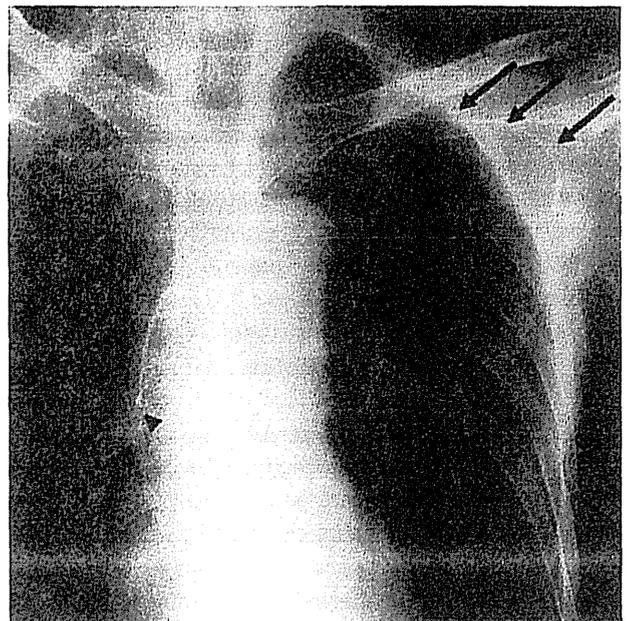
Chest X-ray of an ideally placed central venous port. The curve of the catheter is gentle, and the catheter tip (*arrowhead*) is adjusted to the level of the atriocaval junction. Note the short subcutaneous tunnel (*arrows*) between the venous access site and the implanted port
